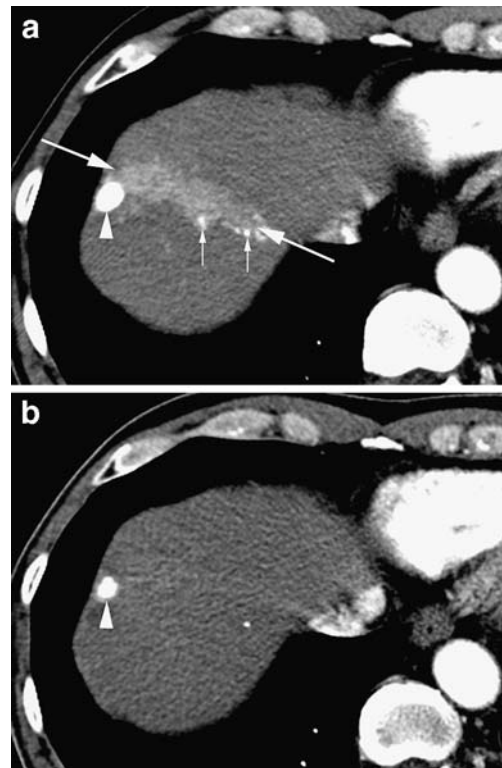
A 49-year-old man who had undertaken two separated sessions of TACEs for a single hepatocellular carcinoma showing THAD without gross appearance of portal portal tract injury. a Arterial phase dynamic CT obtained 4 weeks after the second chemoembolization shows a localized increased attenuation density (large arrows) at the subsegment including the subcapsular iodized-oil accumulation (arrowhead). Iodized-oil densities in the peripheral vascular structures are also demonstrated (small arrows). b Three-month follow-up arterial phase dynamic CT shows disappearance of THAD without gross parenchymal atrophy except the localized contraction of iodized-oil accumulation lesion (arrowhead)
